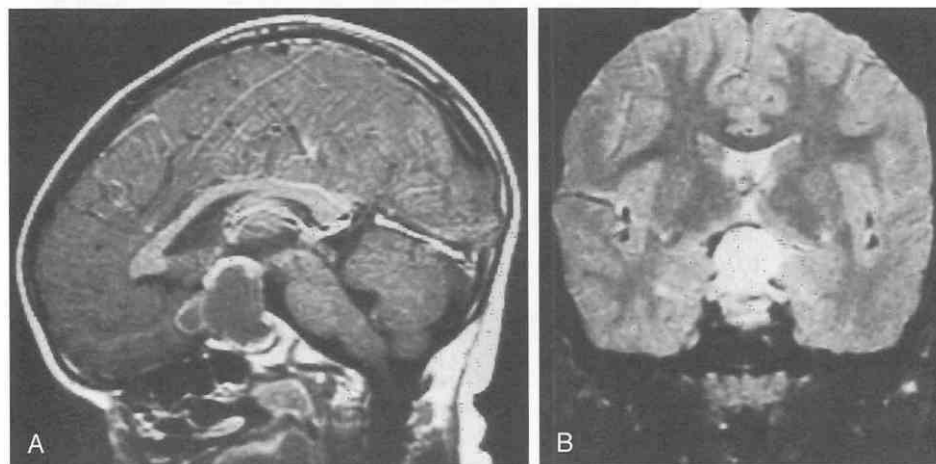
A, T1-weighted sagittal MRI study with gadolinium shows craniopharyngioma, mostly cystic, with sellar extension, and marked elevation of the chiasm, nerves, and tracts. B, Coronal T2-weighted MRI study shows the same patient as in A.
